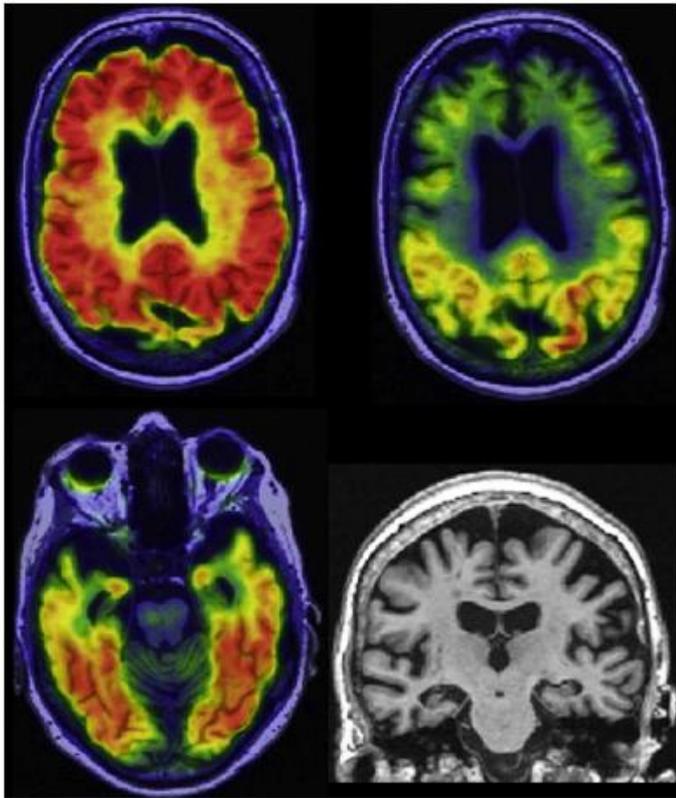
Alzheimer's disease with dementia. A 75-year-old woman with amnesic multidomain dementia. Participant in the Mayo Alzheimer's Disease Research Center. Abnormal amyloid PET with Pittsburgh compound B (top left), tau PET with flortaucipir (top right and bottom left), and atrophy on MRI (bottom right). Biomarker profile A+T+(N)+.
